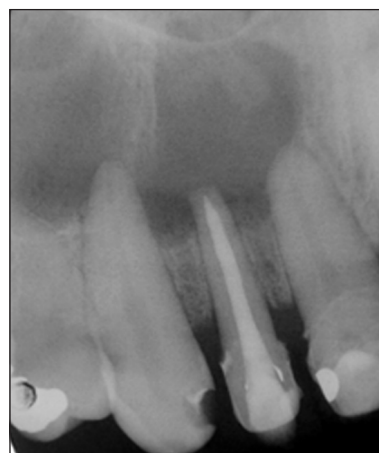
Radiograph taken immediately after obturation.
